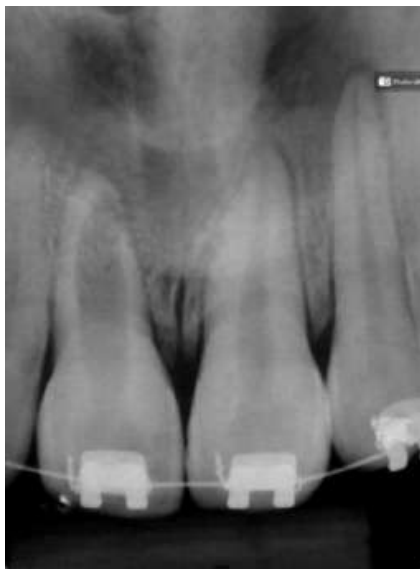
Initial radiograph.
